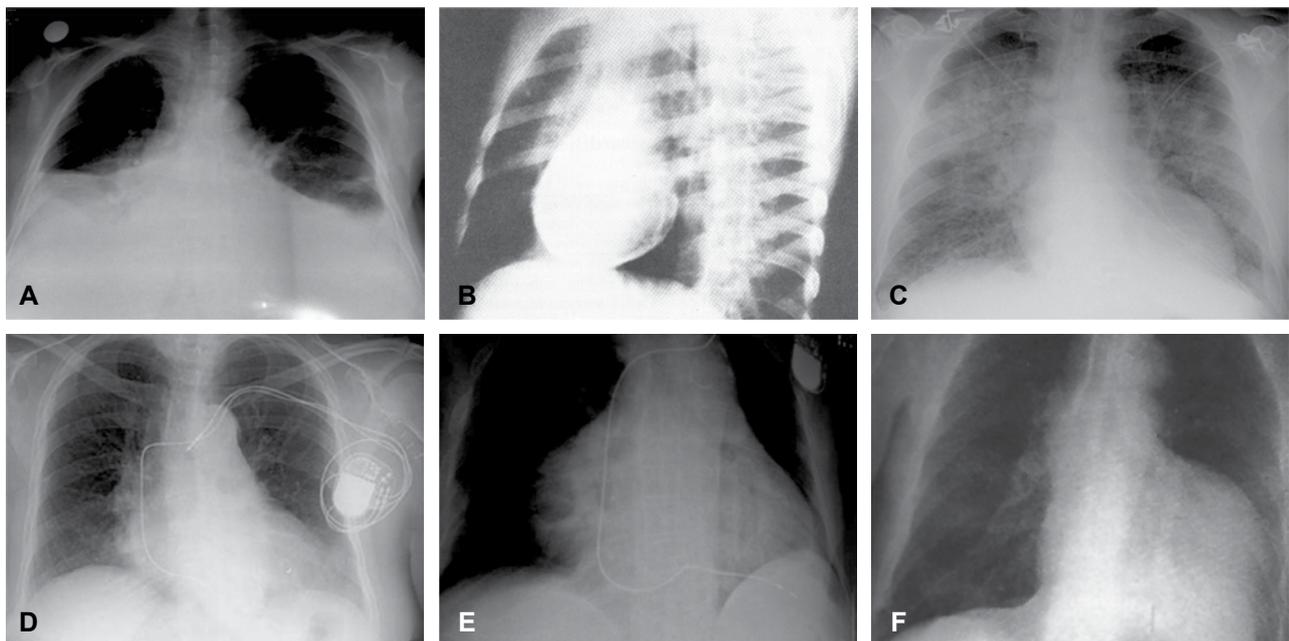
Chest X-ray in heart failure. a) pleural effusion, b) constrictive pericarditis with calcific pericardium, c) pulmonary edema, d) heart failure with pacemaker lead problem, e) cardiomegaly due to right atrial and right ventricular dilatation with small pericardial effusion, f) cardiomegaly with double apex due to left ventricular pseudoaneurysm.
